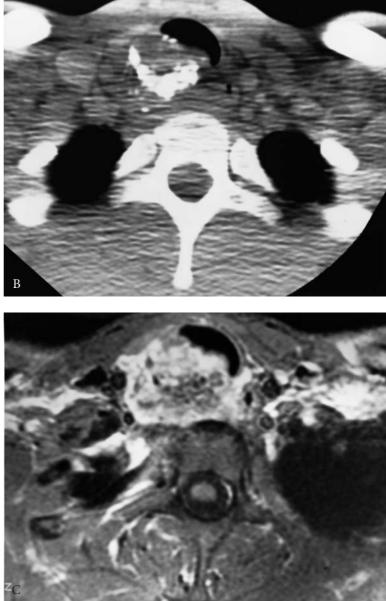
Focal amyloidosis of the left main bronchus. A, The posteroanterior chest radiograph demonstrates a nodularfilling defect in the distal trachea obstructing the left main bronchus with distal left lung atelectasis. B, Computed tomography (CT) scan without intravenous contrast reveals a calcified soft tissue mass obstructing the left main bronchus. C, A CT scan with intravenous contrast demonstrates enhancement within the obstructing left main bronchial lesion. FIGURE 4-47 Focal tracheal amyloidosis. A, Anteroposterior tracheal tomogram reveals a large calcified soft tissue mass nearly obstructing the proximal trachea. B, Computed tomography scan without contrast reveals marked calcification within the mass and extension of the mass into the right paratracheal soft tissues. C, T1-weighted magnetic resonance image of the proximal trachea with gadolinium reveals marked enhancement of the mass.
